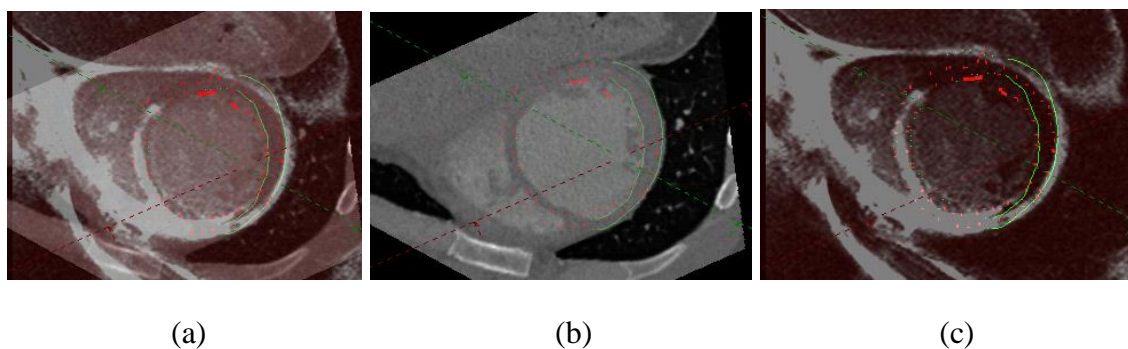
Alignement avant recalage par information mutuelle pour le patient 1 : les deux volumes superposés (a), CT (b) et IRM-RT (c).
